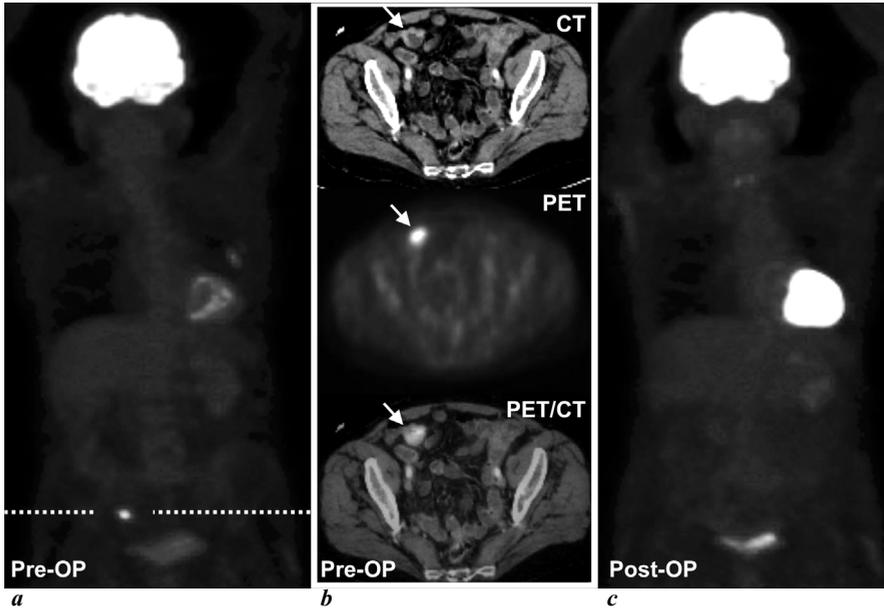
The figure shows the anterior maximum intensity projections of the FDG-PET scan before (*a*) and after surgical resection (*c*) of a solitary melanoma metastasis to the small intestine. *b* Intrinsically coregistered preoperative PET and CT images from the PET/CT. The bowel lesion, which is readily seen on the PET image, is easily missed on CT. The fused image at the bottom provides the clear anatomical correlate of the FDG focus. Note the less intense FDG focus in the chest wall on the preoperative scan, which coincided with the location of a recent biopsy. This lesion, though not treated, was no longer present on the postoperative scan.
